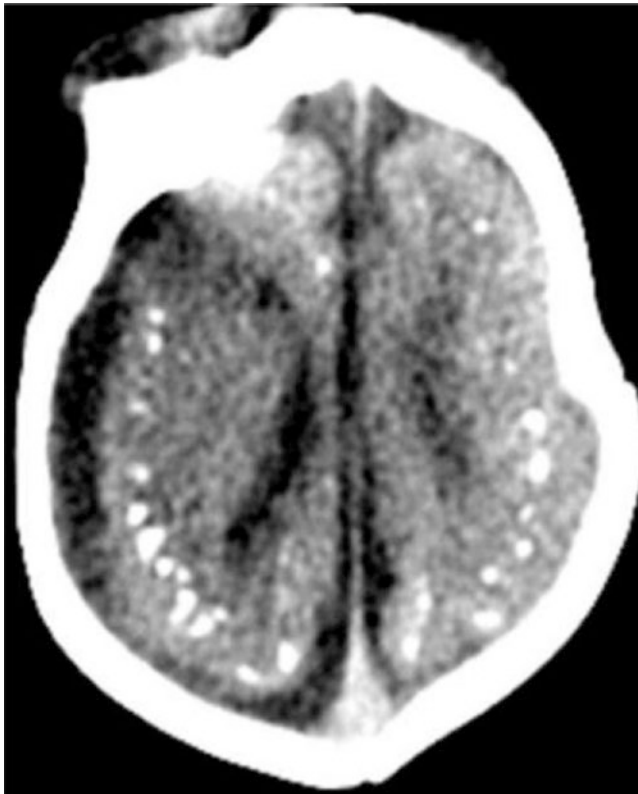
Axial CT image shows diffuse calcifications in cortical/subcortical white matter junction and parenchymal atrophy (Courtesy of Lara Brandão MD, Rio De Janeiro, Brasil)
